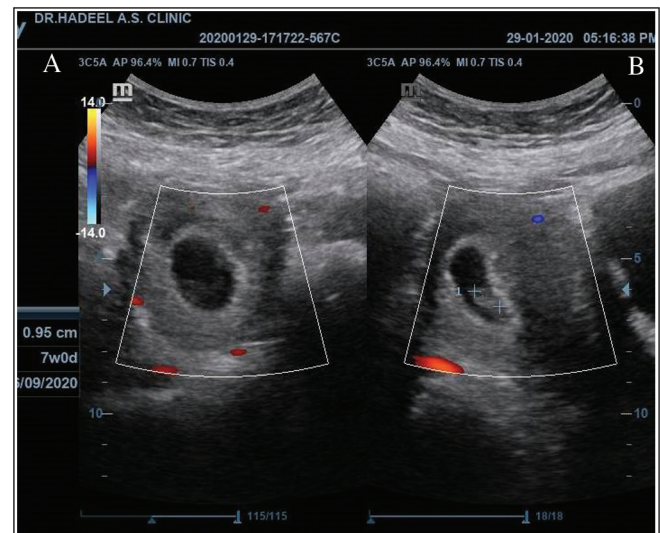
Transverse view of ultrasound scan of gestational sac showed chorionic villi on left superiolateral side of sac. (B) Image at longitudinal view showed anterior location of chorionic villi
